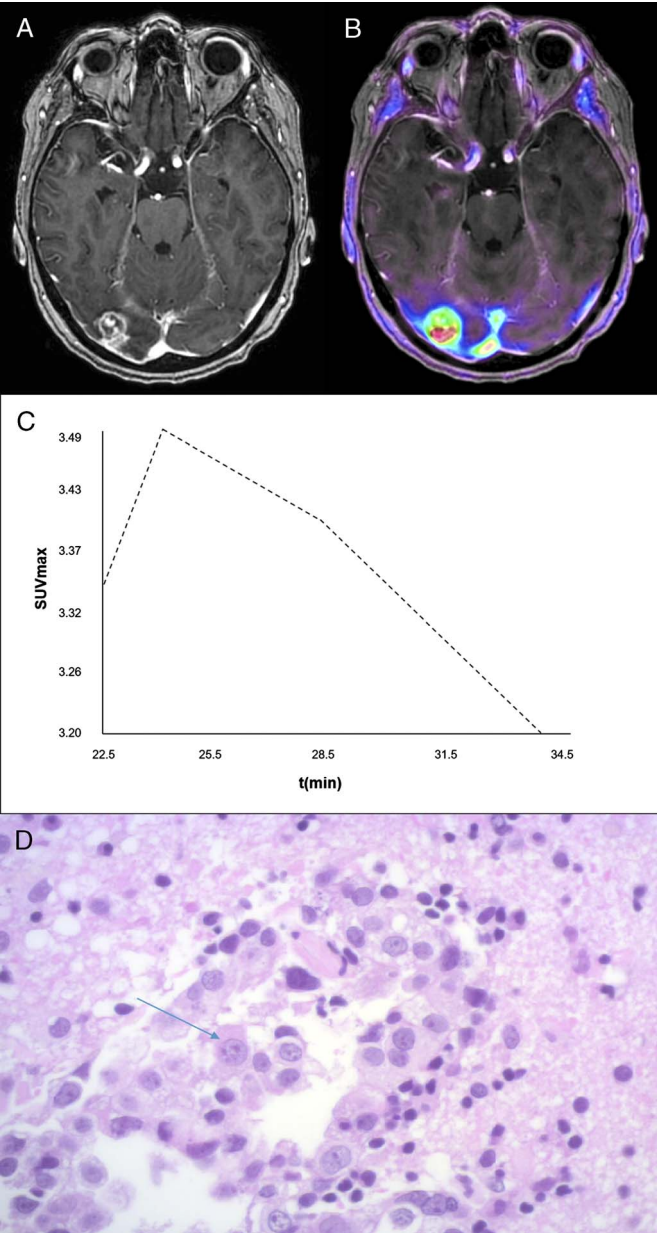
A and B, MRI and ¹⁸F-FET PET/MRI images of a patient with real progression. C, Dynamic ¹⁸F-FET “washout” pattern of the same patient. D, Small clusters of epithelial tumor cells (arrow) within reactive brain parenchyma in resected brain metastasis from the same patient.
